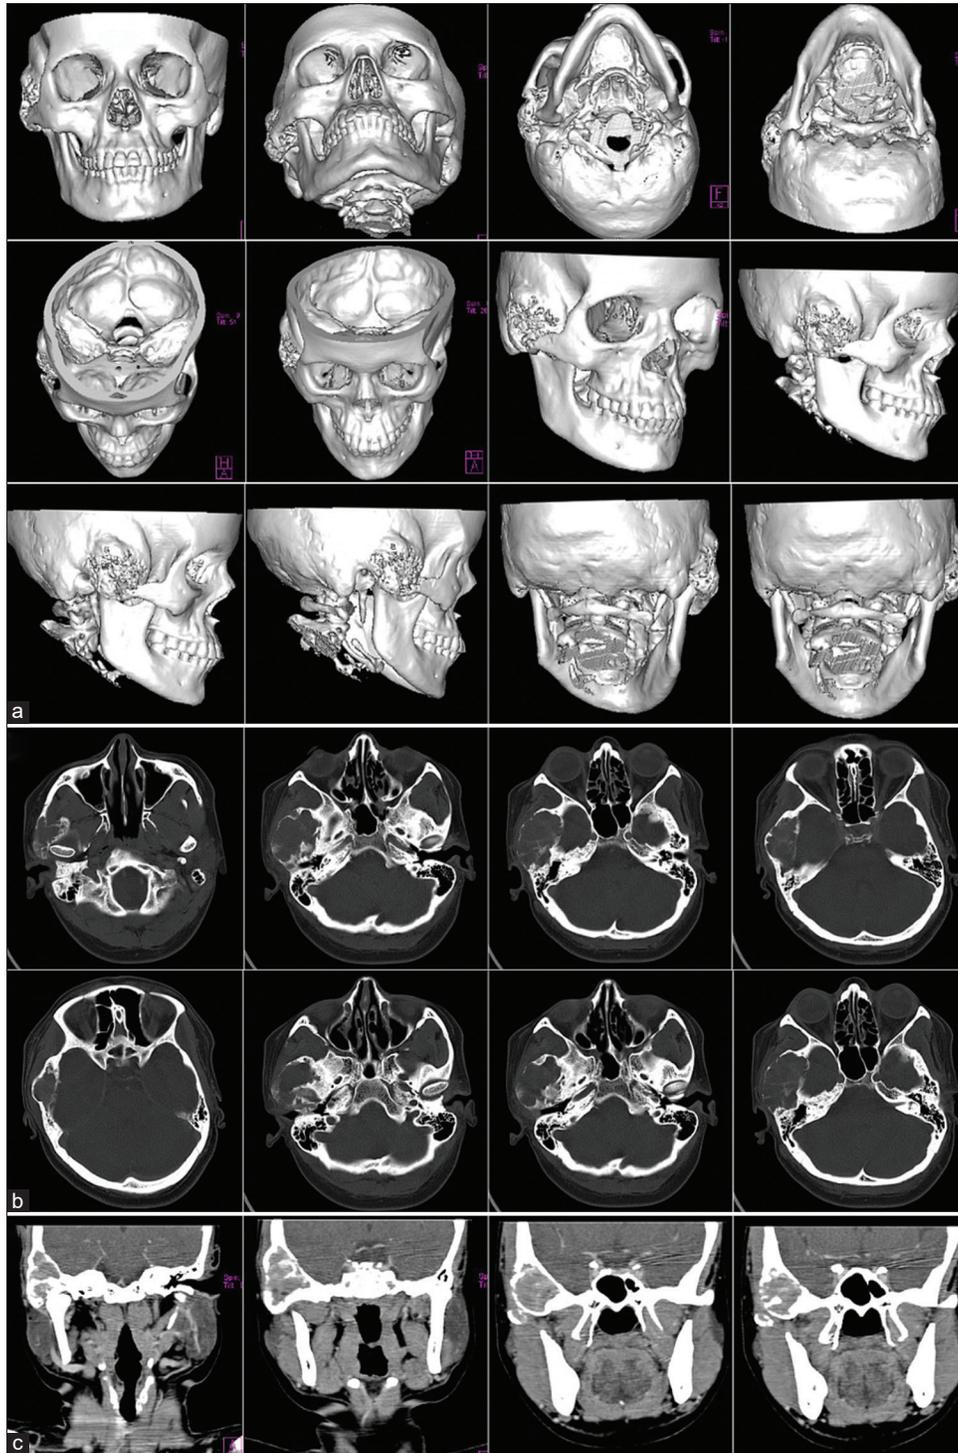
(Case 1) (a) Noncontrast computed tomography revealed a 4.6 cm × 3.7 cm × 5.2 cm (AP × TR × CC) expansile lytic lesion in the squamous part of the right temporal bone extending to involve the zygomatic arch. It encroached on the right infratemporal fossa and middle cranial fossa with no invasion of structures in these spaces. (b and c) On contrast-enhanced computed tomography imaging, the lesion exhibited mixed radiopaque-radiolucent appearance, with no distinct zone of transition from the adjacent normal bone, suggestive of fibrous dysplasia. Outer cortex appeared thinned out with cortical breaches in numerous places
